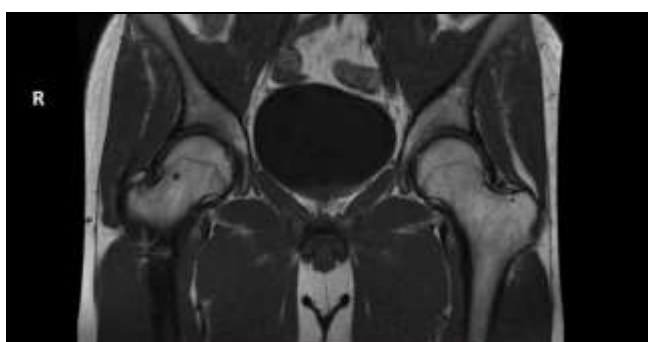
MRI section before the operation. June 2016
